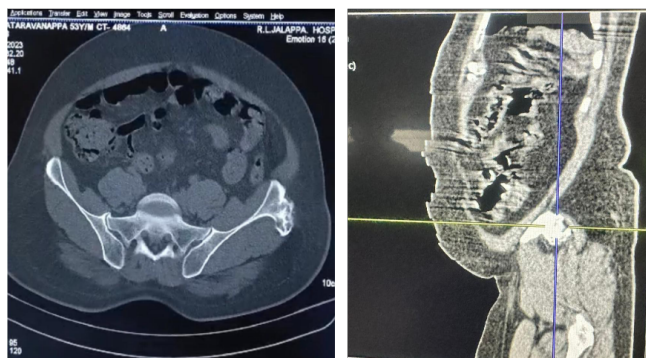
(a) CT pelvis axial view and (b) CT pelvis with 3D reconstruction
